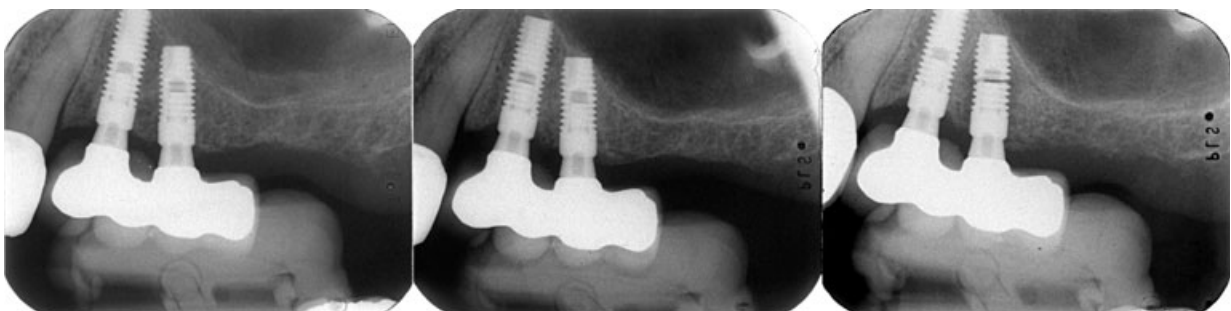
Fracture of the implant pillar seen in radiographs taken 2 years after bridge installation. Neither the image from the latter occasion, nor the one taken at a 1-year control examination show any sign of fracture. Notice the inflammatory reaction along both sides of the implant.
